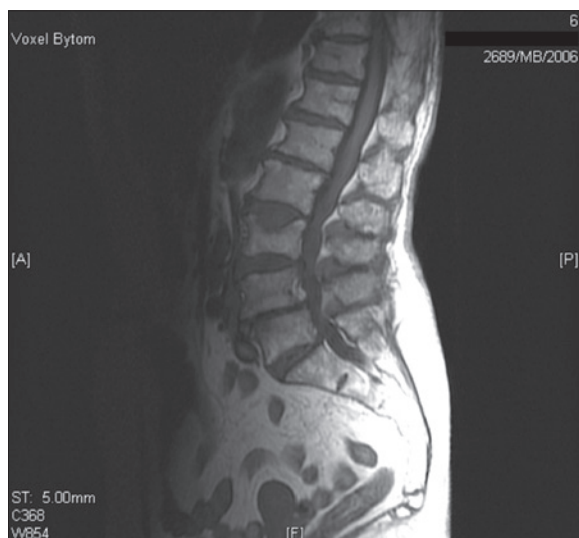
T1-weighted magnetic resonance scan obtained in a patient diagnosed with the RA subtype of myelodysplastic syndrome.
